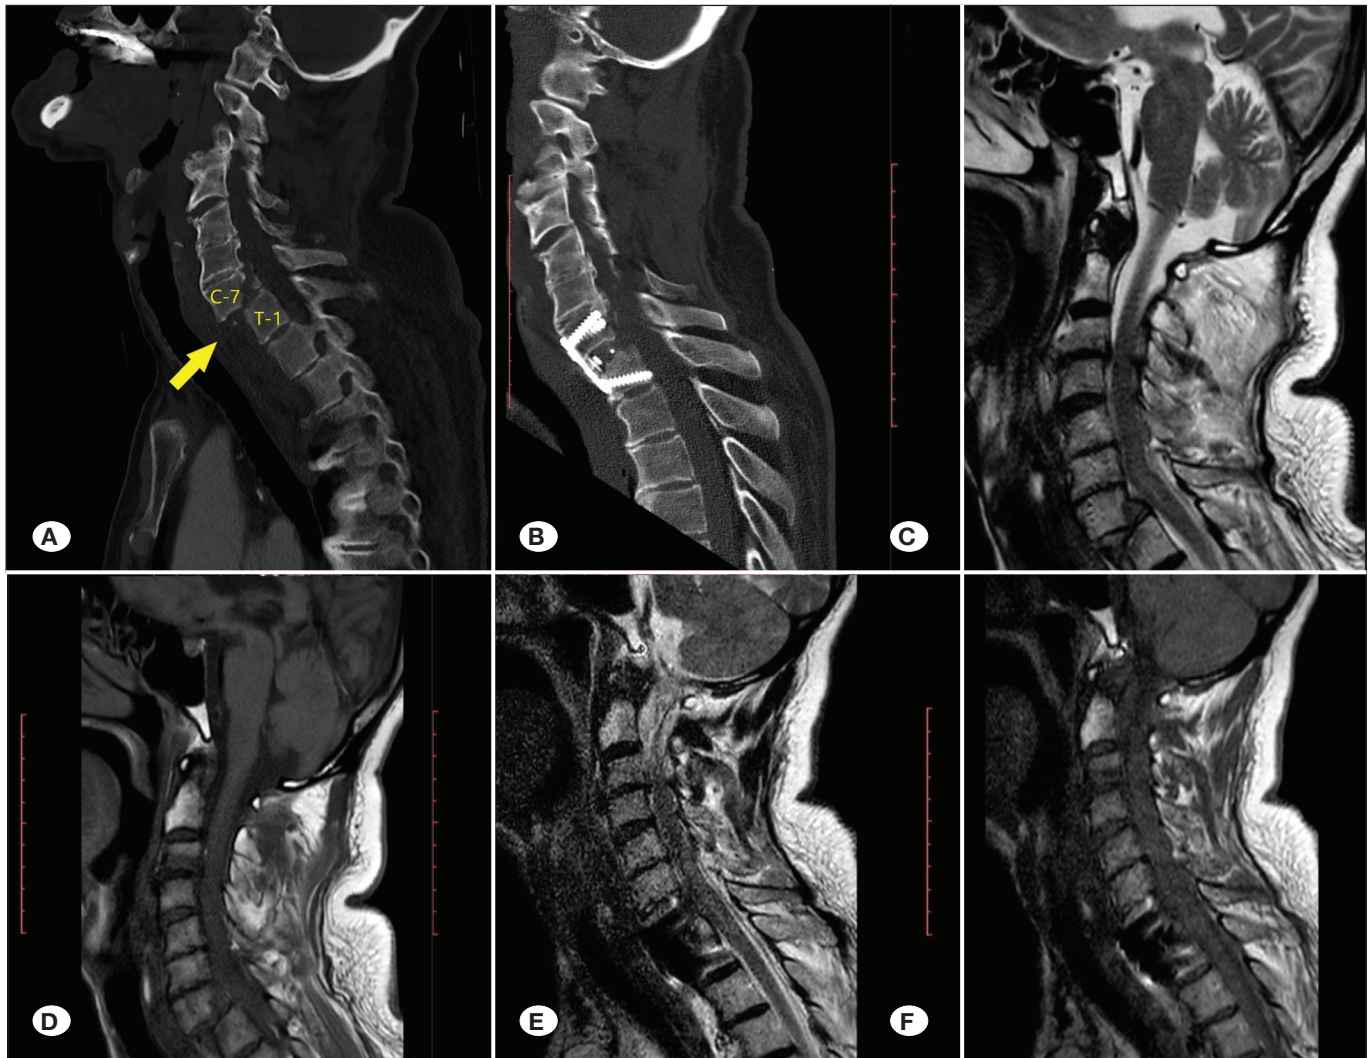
C7-T1 anterior dislocation + anterior fusion A) Preoperative CT, B) Postoperative CT, C-D) Preoperative T2-T1 MRI, E-F) Postoperative T2-T1 MRI. The yellow arrow indicates the fracture area. CT: Computed tomography, MRI: Magnetic resonance imaging.
